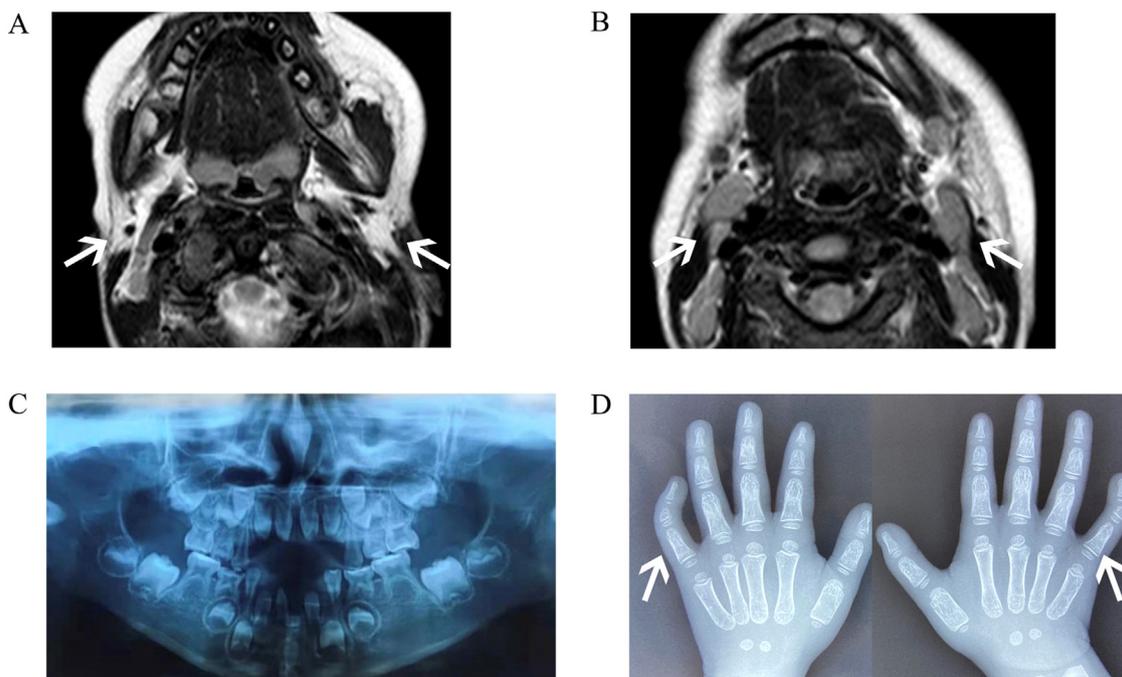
Imaging findings of patients. MRI showed no visible parotid glands (A, arrow) and small bilateral submandibular glands (B, arrow). Panoramic tomography showed the absence of bilateral second mandibular premolars and right mandibular incisor (C). X-ray showed symmetrical clinodactyly in the fifth fingers (D, arrow).
